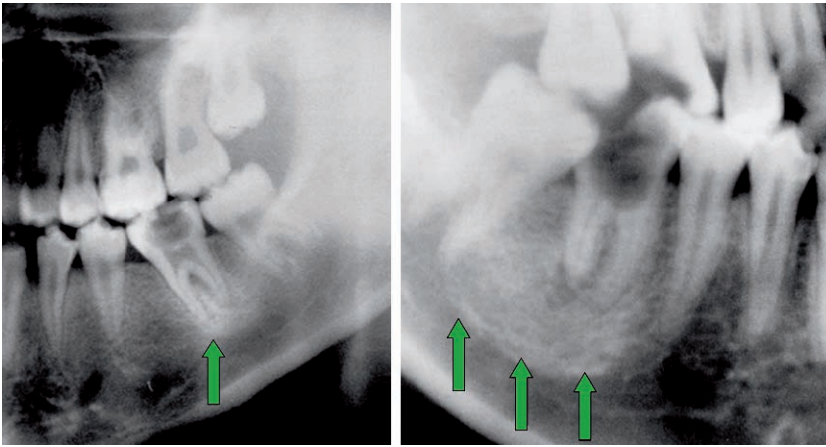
Details from panoramic radiographs demonstrating examples of focal sclerosing osteomyelitis (condensing osteitis). In both instances, bony sclerosis is seen beyond the apical rarefactions subjacent to the carious first molar tooth (*arrows*)
